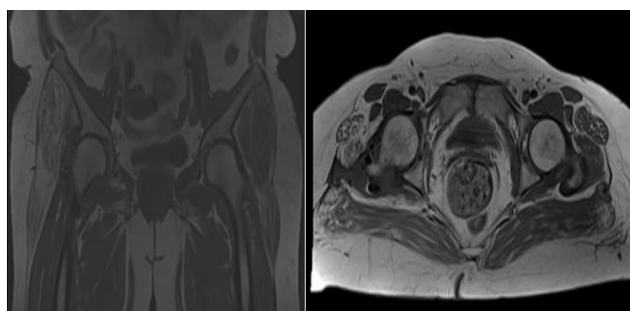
No sign of avascular necrosis on magnetic resonance imaging at 6th month follow up of patient
